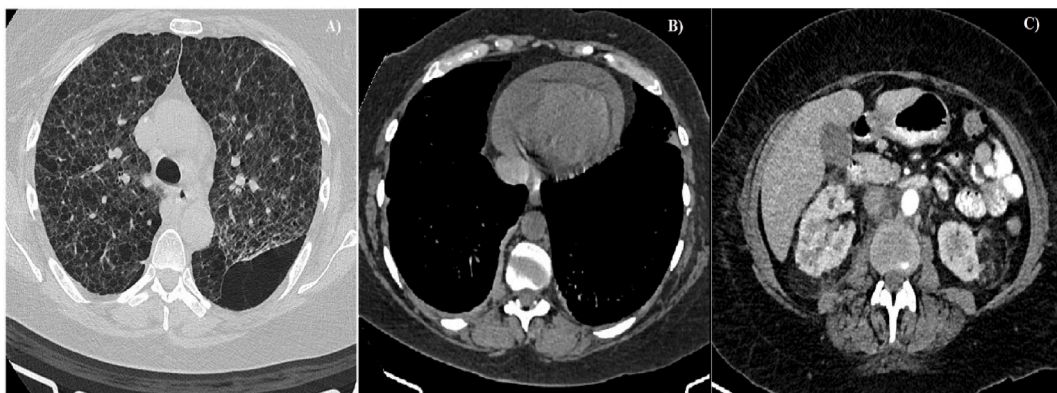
a) HRCT shows septal thickening, panlobular emphysema and a subpleural basal left bulla. b) Tomographic scan revealing the presence of pericardial effusion. c) Renal cysts with hematuria remnants are observed in the middle third of both the right and left kidneys. An adenopathy is observed at the aorto-caval region.
